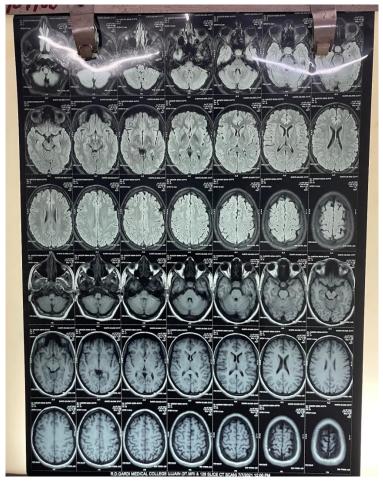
MRI Suggestive Of Pituitary Adenoma.
